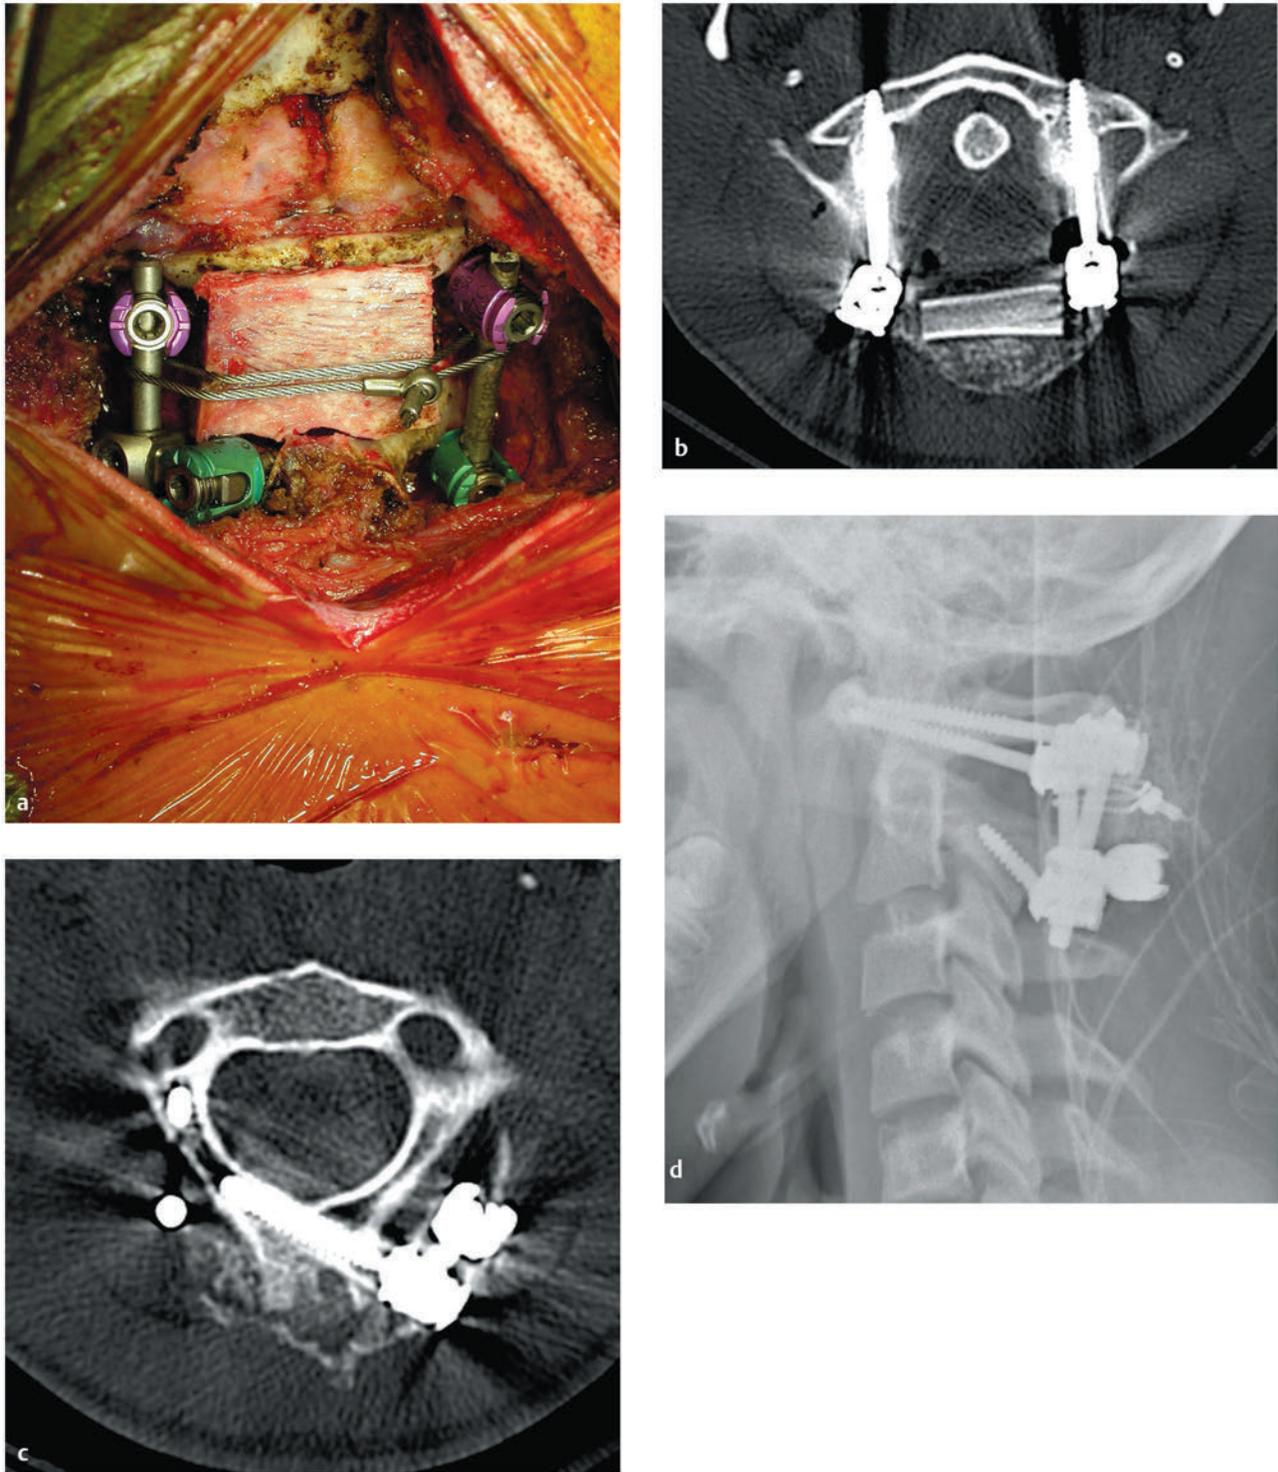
Translational C1–2 subluxation. (a) Intraoperative photograph and (b,c) axial computed tomographic scans of a modified Goel-Harms type of fusion construct performed in the patient from ▶ Fig. 61.3 with traumatic C1–2 subluxation.^{63,64} Bilateral C1 lateral mass screws were placed and connected via metallic rods to the right C2 pars and left C2 laminar screws. An iliac crest bone graft was cabled in place between the posterior arch of C1 and the spinous process of C2. (d) Postoperative lateral radiograph of the fusion construct.
